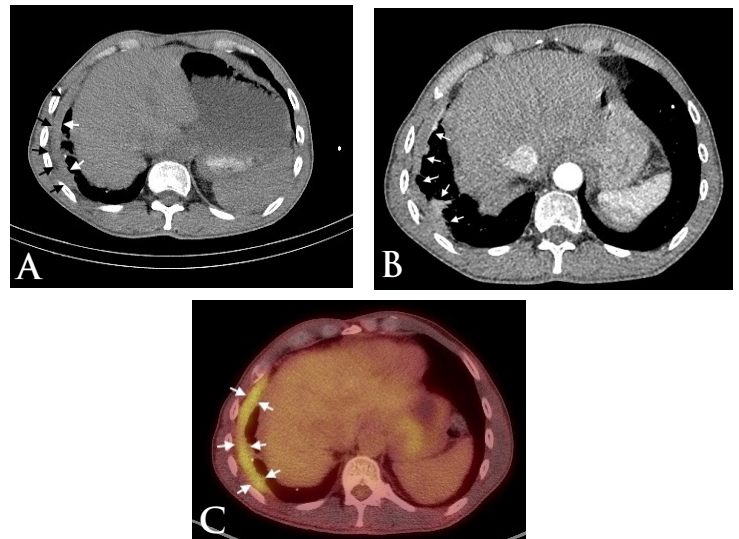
Images of malignant mesothelioma (Case #7). A: Initial image from CTAC; B: Chest CT; C: PET scan. Abbreviation: CT - computed tomography; CTAC - CT attenuation correction; PET - Positron Emission Tomography. Arrow points at the mass.
